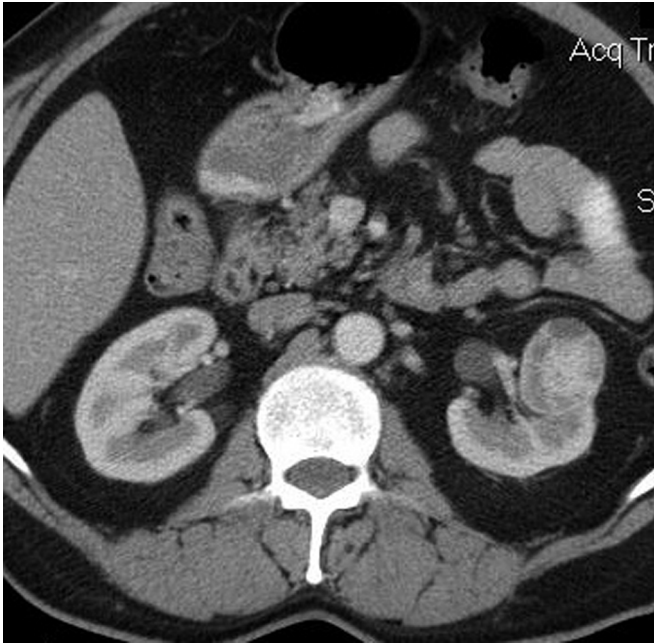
Computed tomographic (CT) scan showing a 4-cm heterogeneously enhancing centrally located mass in the mid pole of the left kidney.
